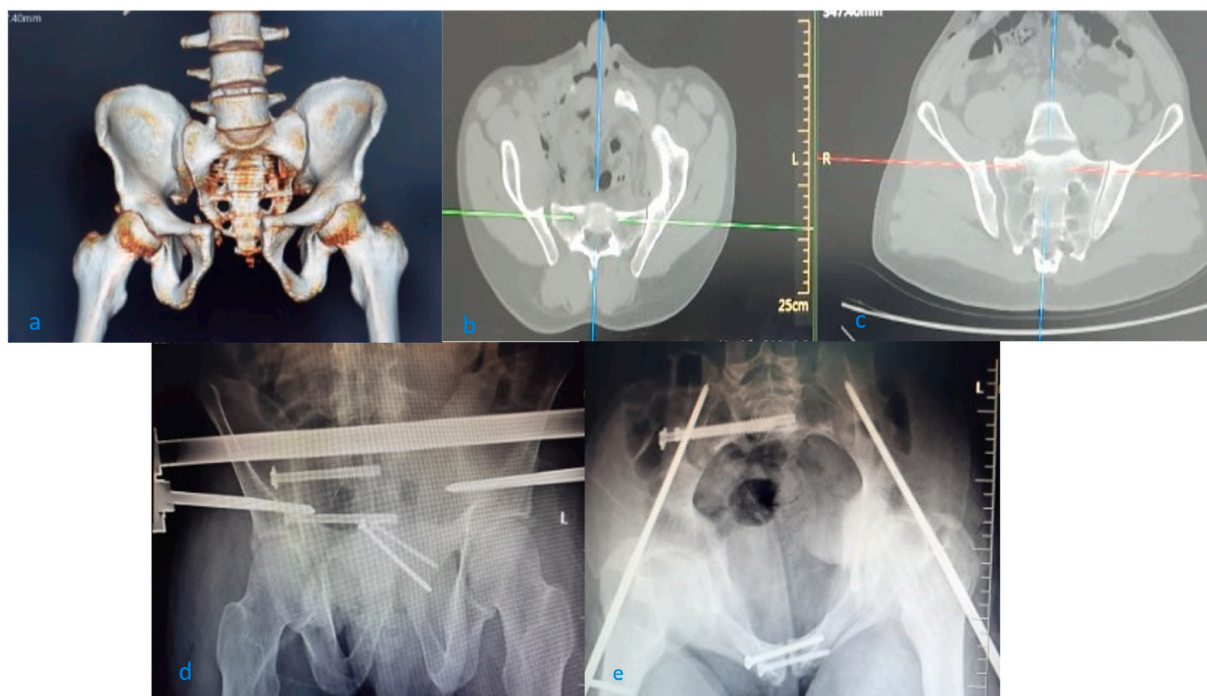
(a)(b) and (c); CT scans showing an APC III injury with right sacroiliac (S–I) diastasis plus avulsion fracture of the sacrospinous ligament, for one of our patients. (d) Outlet and (e) Inlet view pelvic x-rays showing the right S1 and S2 screws, interfragmentary 3.5 mm symphysis screws and supra-acetabular anterior pelvic external fixator.
